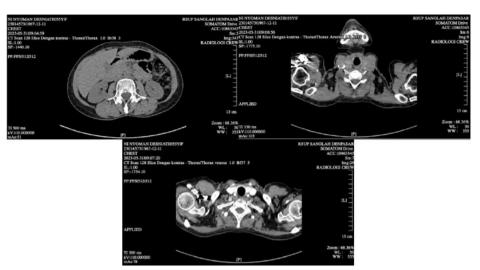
Patient's Chest CT Scan Results.
